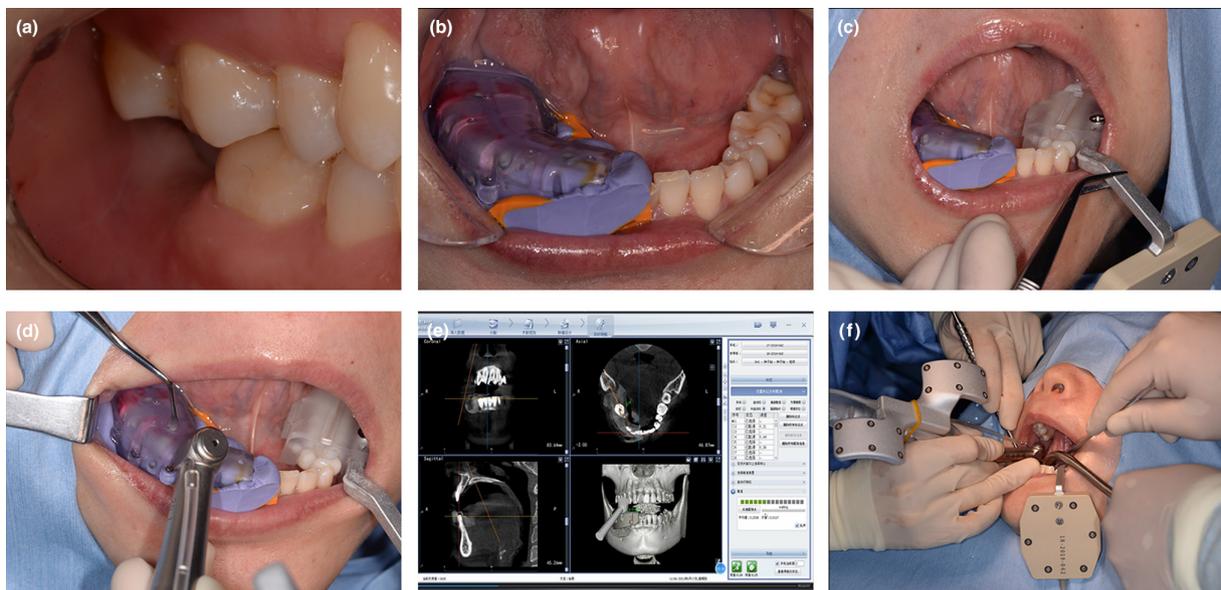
U-shaped tube registration method: (a) the edentulous area of a 40-year-old female (tooth 47 missed); (b) a U-shaped tube registration device fitted in the surgical site prior to CBCT imaging; (c) the U-shaped tube registration device and the reference device with the fixation device placed on the patient intraoperatively; (d) U-shaped tube registration; (e) U-shaped tube registration in software; and (f) implant surgery under the dynamic navigation system.
